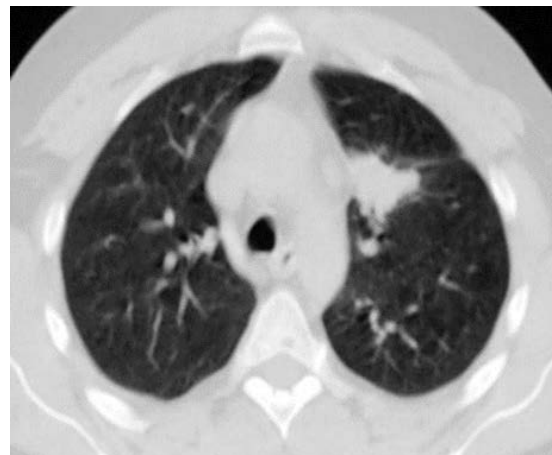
Chest computed tomography scan shows partial response to treatment.
